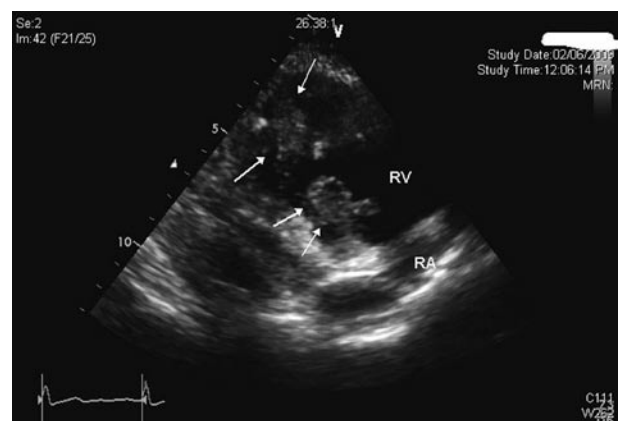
Parasternal view showing right ventricular masses (RV inflow)
